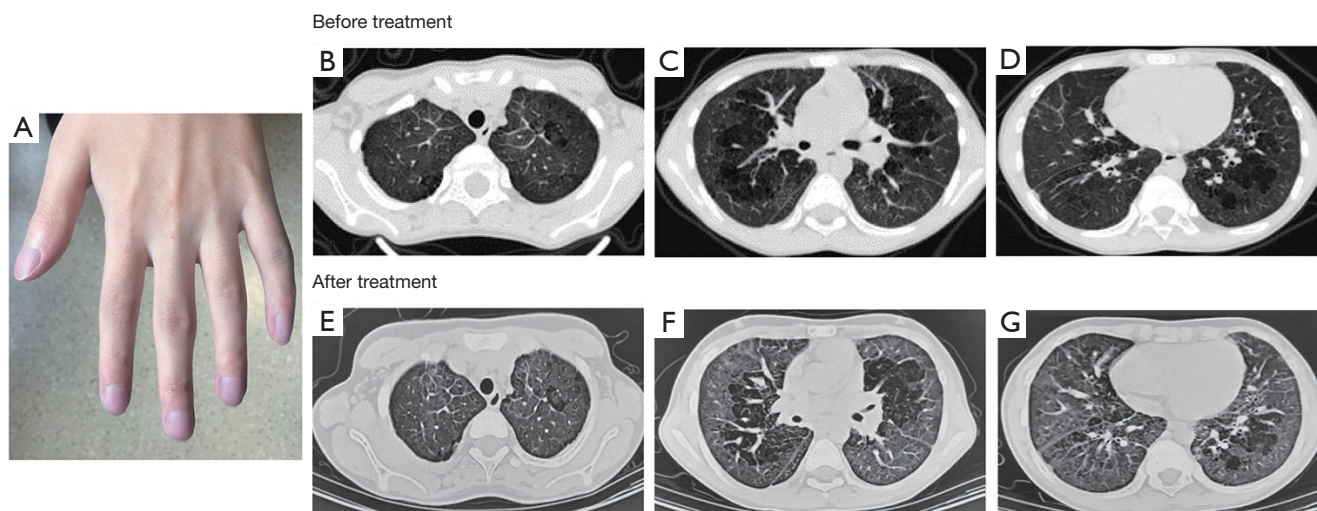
Clinical manifestations and chest image of case 2. (A) Clubbing fingers of case 2. (B-G) Chest high-resolution computed tomography scan of case 2. Diffused ground-glass opacities and focal lung hyperinflation in case 2.
